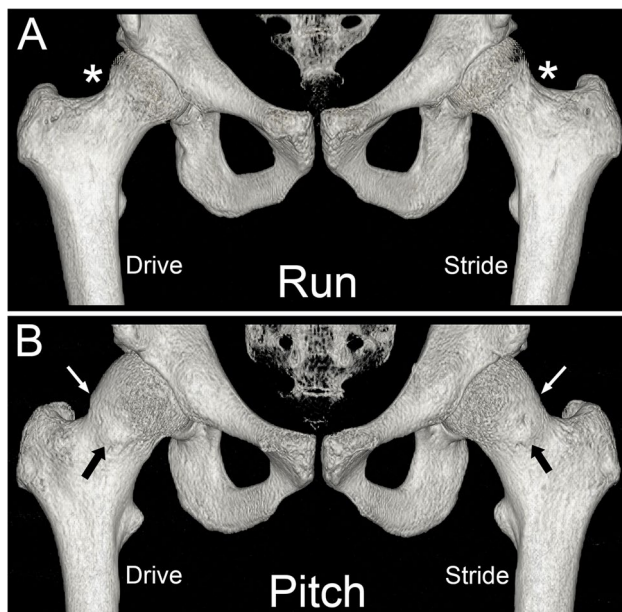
Three-dimensionally reconstructed CT scans in a runner (A) and baseball pitcher (B). Alpha angles bilaterally at the femoral head-neck junction (*) in the runner ranged from 33.3° to 40.1°, depending on clock position. In the baseball pitcher, bilateral cam morphologies (alpha angles $\geq 60^\circ$) were present superiorly (white arrows) and anteriorly (black arrows) with larger defects in the drive leg. Alpha angle in the drive leg was 82.4°, 84.7°, 68.2°, and 67.5° at the 12, 1, 2, and 3 o'clock position, respectively. In the stride leg, alpha angle at the 12, 1, 2, and 3 o'clock position was 77.9°, 77.6°, 71.2°, and 65.6°, respectively
